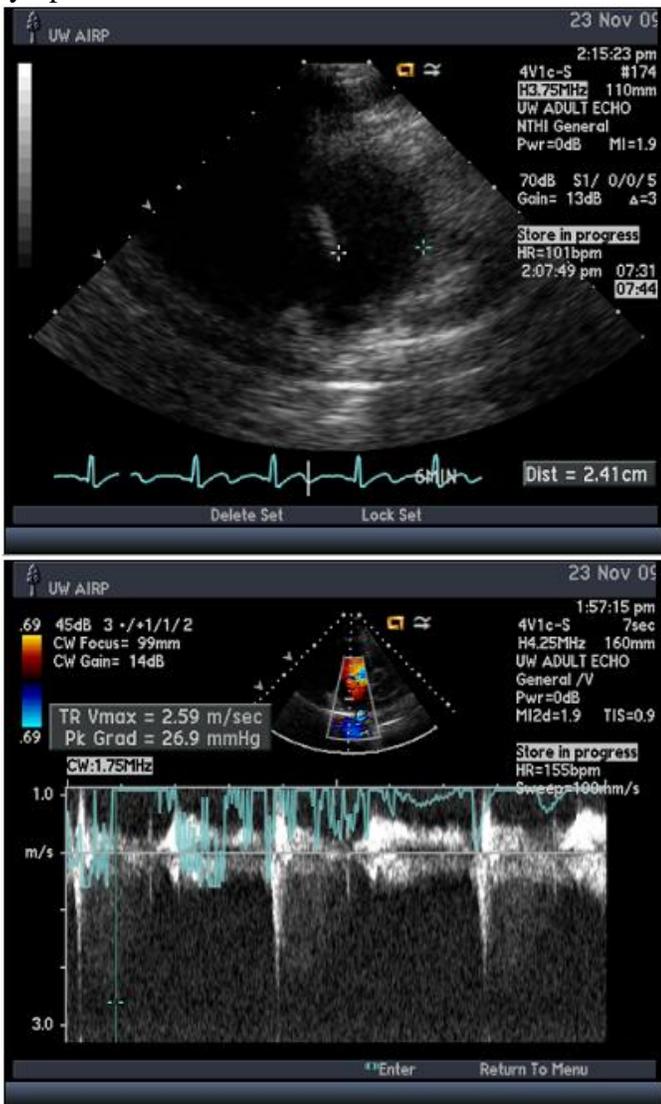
Tricuspid Regurgitant jet. The top image shows the tricuspid valve. The bottom image shows the tricuspid jet velocity. The white waveform along the bottom half of the image charts the magnitude of the jet velocity against time (Ultrasound acquired image).
